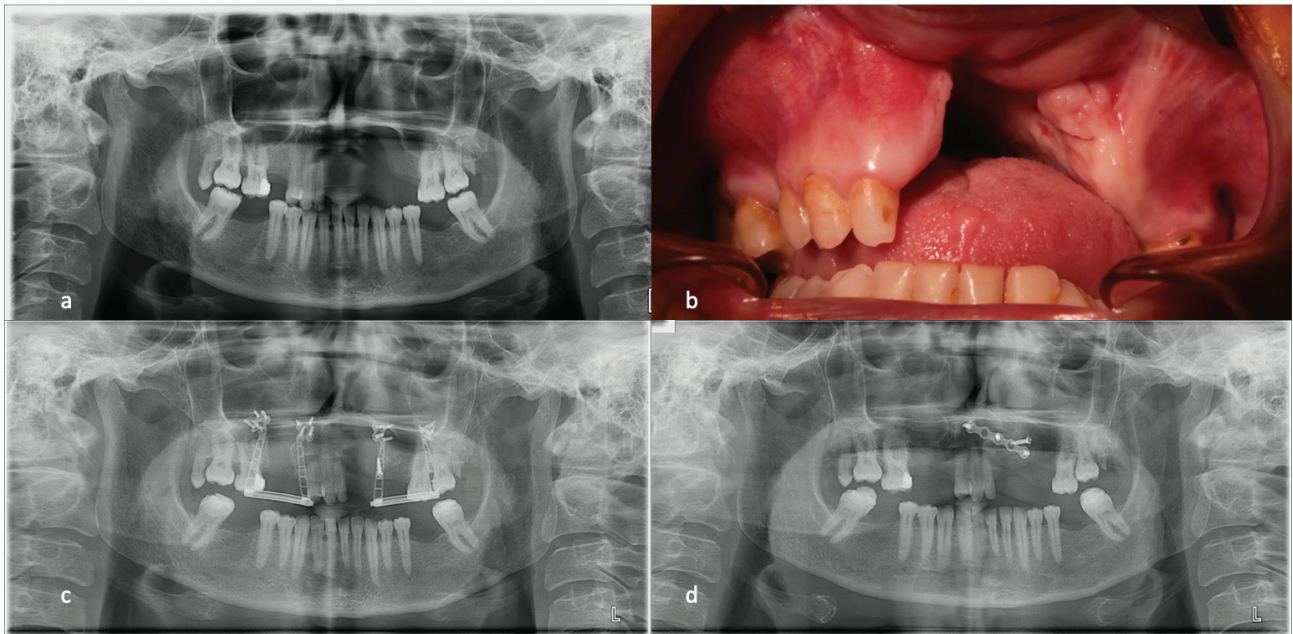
a) preoperative view of the patient with wide defect, b) intraoral view of the defect, c) after the activation phase of the distraction, d) final radiographic view after the khoury technique
